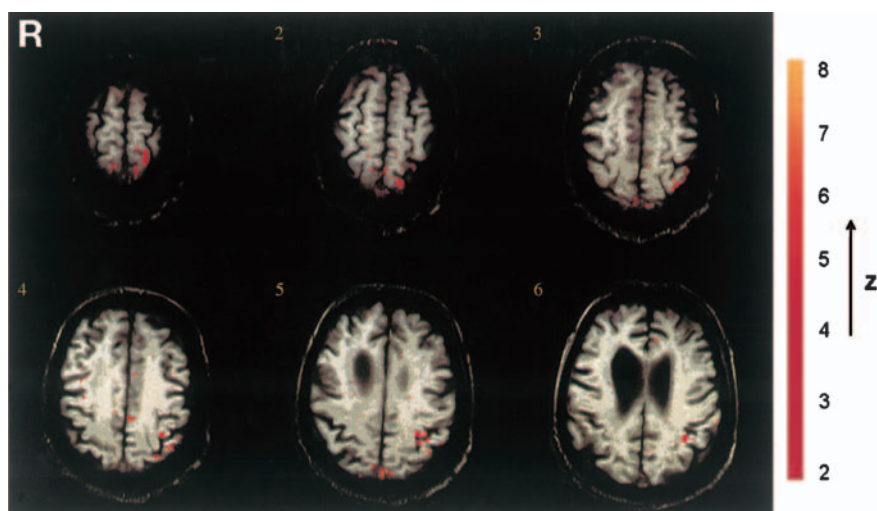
Functional magnetic resonance images 3 months after ventriculoperitoneal shunting showing a significant signal increase in the left peri-rolandic cortex with right hand exercise.
